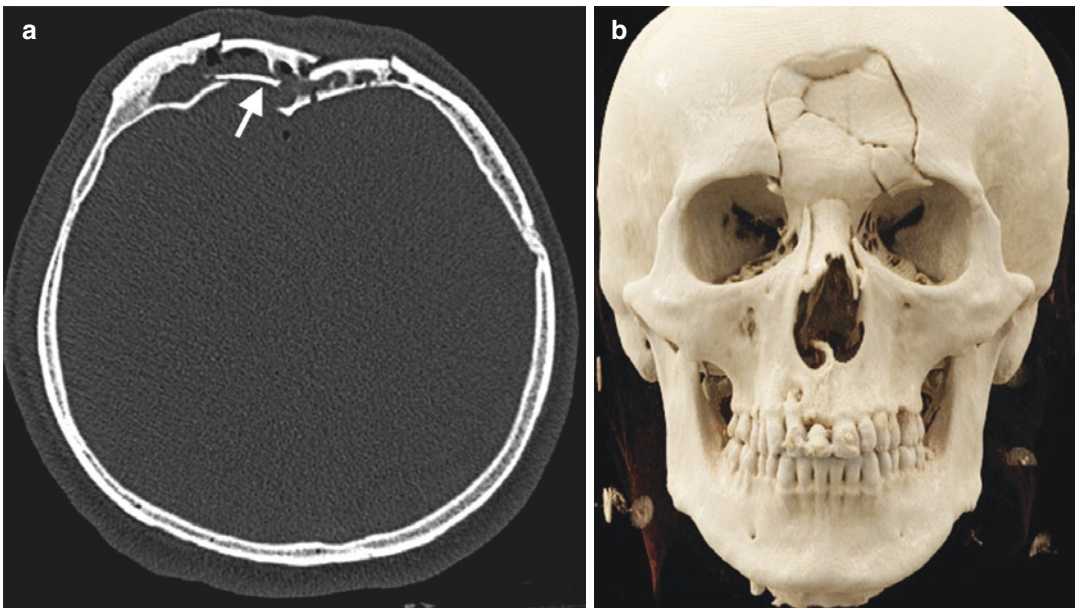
Comminuted fracture of frontal sinus. Axial CT (a) and (b) CR image demonstrate comminuted fracture of frontal sinus with multiple fracture fragments (arrow)
